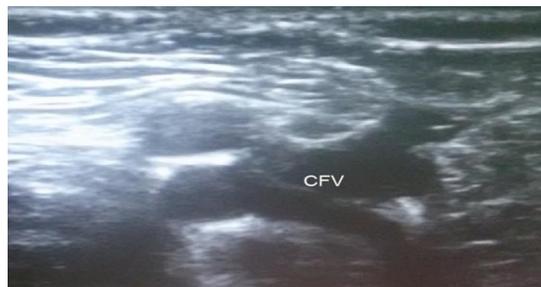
Venous ultrasound with compression of the leg veins; CFV . commen femoral vein .
